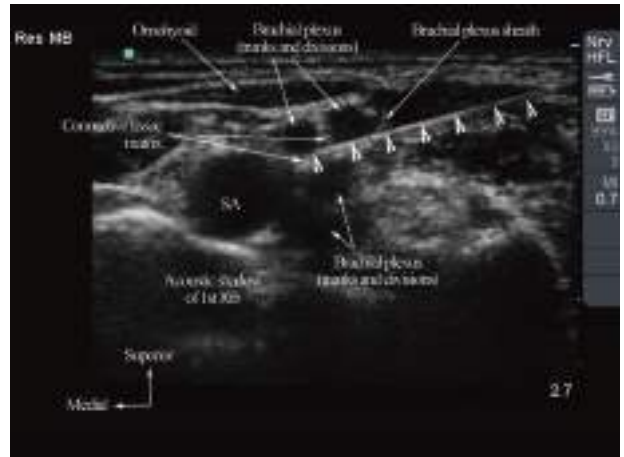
Transverse sonogram of the supraclavicular fossa showing subfascial placement of the needle tip. Note the needle (white arrow heads) has traversed the brachial plexus sheath, and its tip is lying in the connective tissue matrix inside the supraclavicular nerve cluster. SA indicates subclavian artery.
